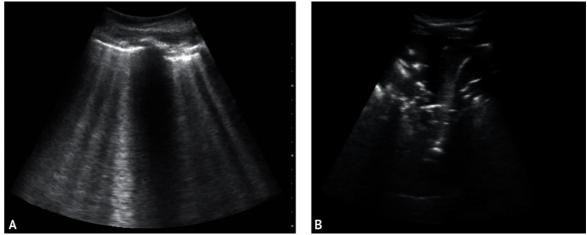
Ultrasonic signs of lung tissue lesion. A is a sign of infiltration (B-line), B is a sign of consolidation (tissue sign)
